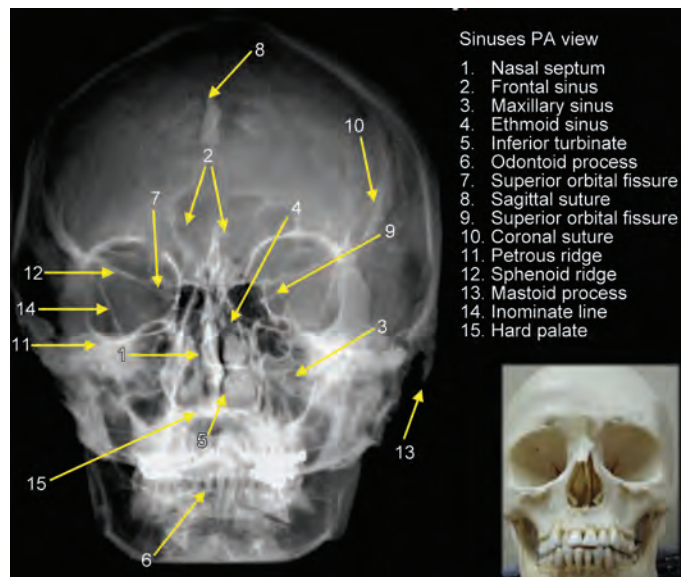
Coronal view of skull X-ray.
